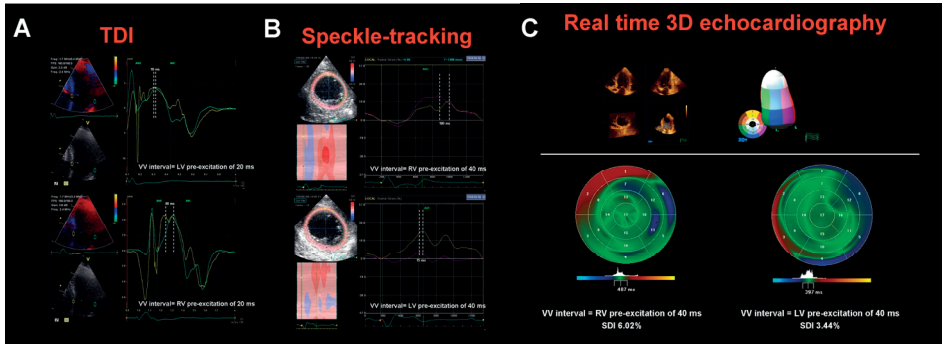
Examples of VV interval optimizations by measuring LV mechanical dyssynchrony. Panel A. Tissue Doppler imaging (left) permits the assessment the time difference between peak systolic velocities of 2 opposing walls (septal and lateral wall). Panel B. Speckle-tracking echocardiography (middle) permits the assessment of radial dyssynchrony from the parasternal short axis view at papillary muscle level. Radial dyssynchrony is defined as the time difference between the peak systolic radial strain of the antero-septal and posterior wall. Panel C. Real time 3D echocardiography (right) permits the assessment of systolic dyssynchrony index (SDI). The LV 3D model is automatically subdivided in 17 standard wedge-shaped (apart from the apex) subvolumes. For each volumetric segment, the time interval to reach the minimum systolic volume is automatically calculated. The standard deviation of these timings for 16 segments (excluding the true apex) is expressed as a percentage of the cardiac cycle, obtaining the SDI.
